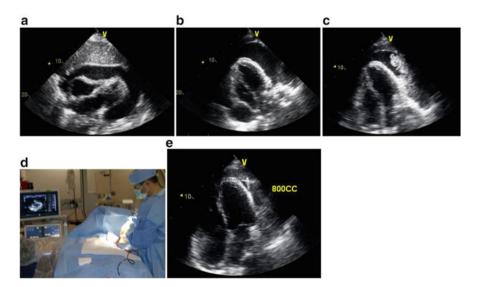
Echocardiogram study demonstrated a large pericardial effusion with associated tamponade physiology in a 73-year-old woman with breast cancer and new-onset dyspnea. (a) Large effusion in the subcostal view with evidence of right ventricular collapse. ($\mathbf{b} - \mathbf{e}$) Apical 4-chamber views demonstrating effusion before (\mathbf{b}) and during (\mathbf{c} and \mathbf{d}) pericardiocentesis. The bright density in the pericardial space (\mathbf{d}) represents saline contrast bubble injection used to confirm the position of the catheter tip in the pericardial space. (\mathbf{e}) Echocardiogram demonstrating minimal residual effusion after evacuation of 800 mL of fluid
